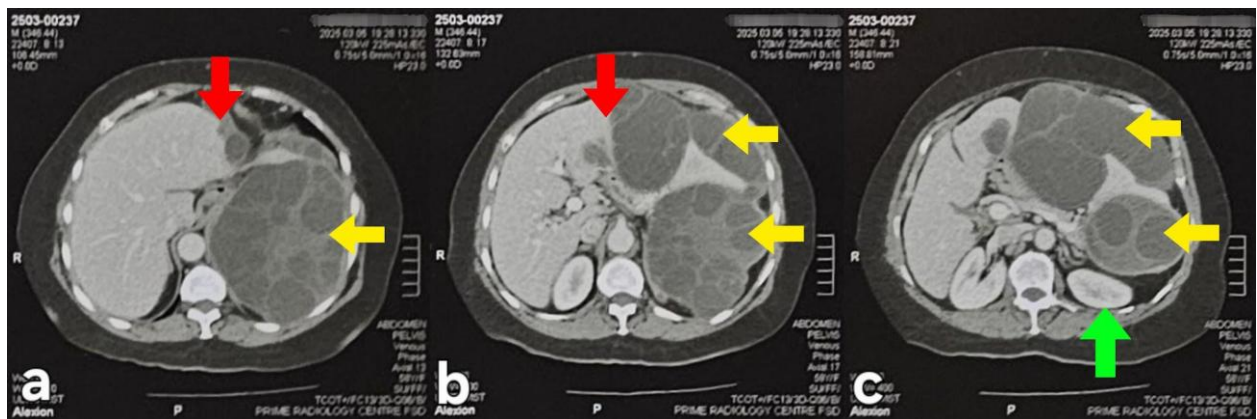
Axial contrast-enhanced CT images. (a) The cyst shows a multivesicular daughter-cyst pattern (yellow arrow) with medial displacement of the left hepatic lobe (red arrow). (b) Marked mass effect with thinning and molding of the left hepatic lobe against the cyst (red arrow), consistent with pressure-related compression. Multiple daughter cysts are visible (yellow arrows). (c) Inferior displacement of the left kidney (green arrow) which appears more caudally due to the hydatid cyst (yellow arrows).
